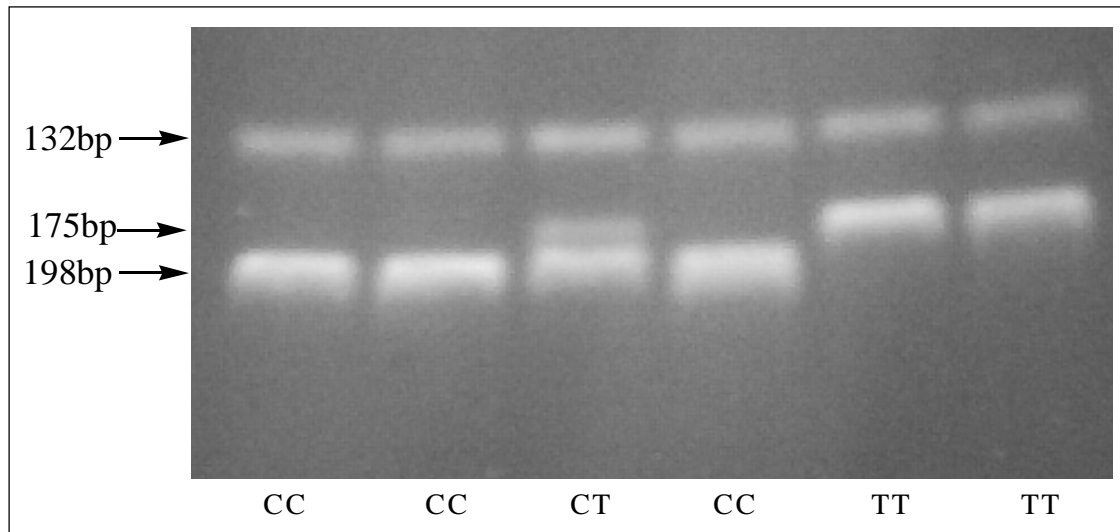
Visualisation of the MTHFR C677T polymorphisms. CC, CT, and TT refers to the MTHFR 677 genotypes. The 132bp fragment is the *HinfI* digested fragment from the developed 150 bacteriophage lambda internal control. The 175 and 198bp fragments are the fragments generated by *HinfI* digestion of the amplified DNA segment of genomic DNA of the subjects
